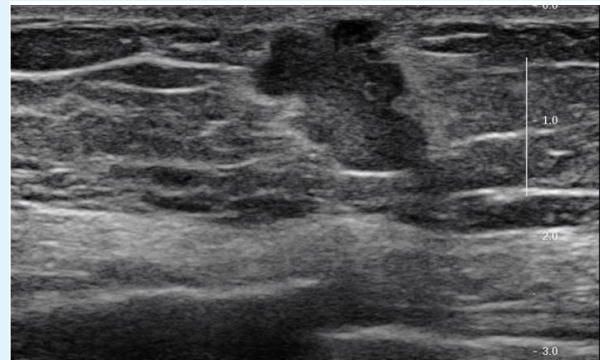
Grayscale ultrasound image of the right breast demonstrates a subareolar taller than wide irregular hypoechoic mass with lobular and angular margins.
